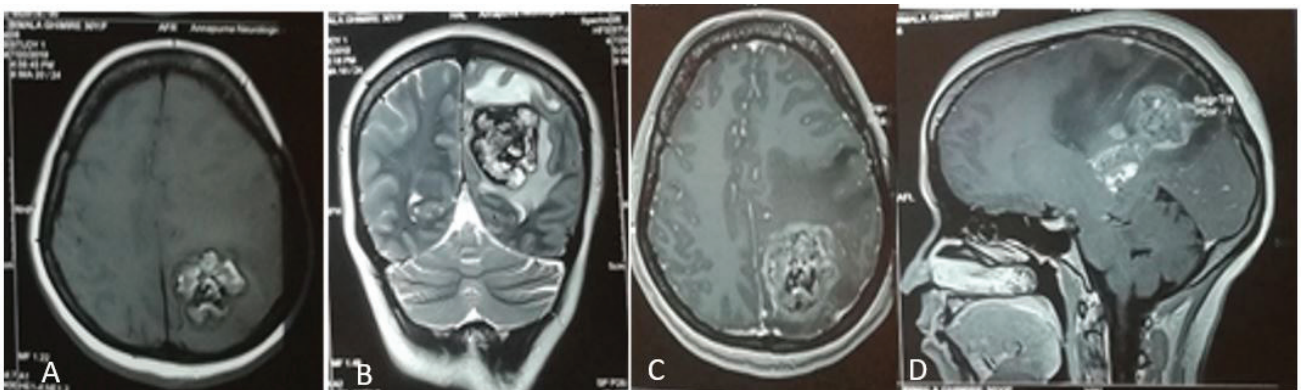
MRI (A: Plain T1 axial; B: Plain T2 coronal; C: contrast axial; D: contrast Sagittal)
